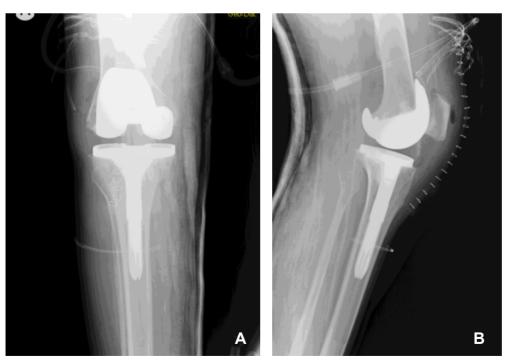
Haemophilic arthropathy of the knee joint, X-ray after surgery (a and b)
